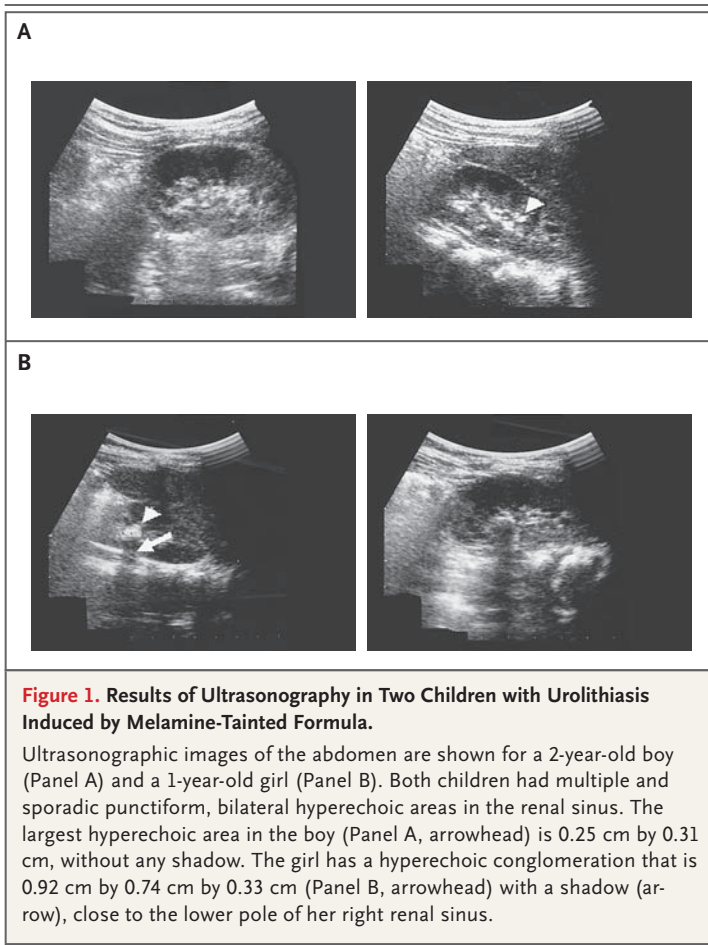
Results of Ultrasonography in Two Children with Urolithiasis Induced by Melamine-Tainted Formula.
